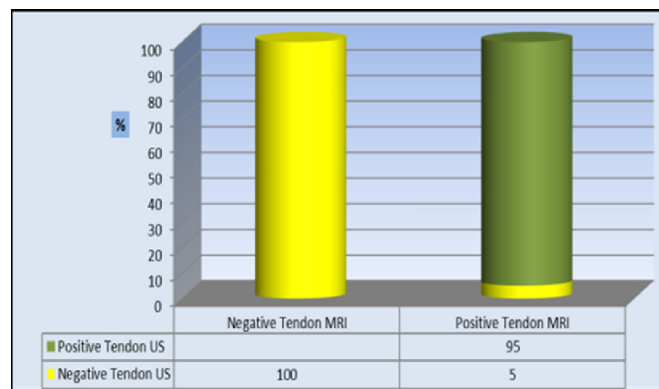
Representing tendon injury results diagnosed by ultrasonography.
